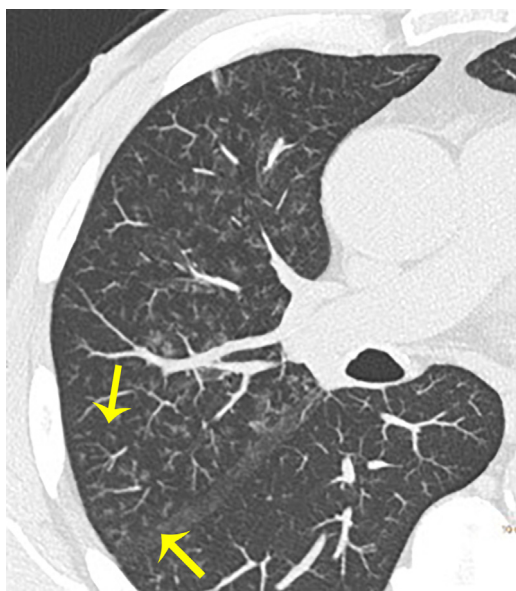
Pyogenic airway disease. Thin maximum intensity projection reformatted CT image shows diffuse centrilobular branching nodular and linear opacities resulting in a tree-in-bud appearance (arrows).
